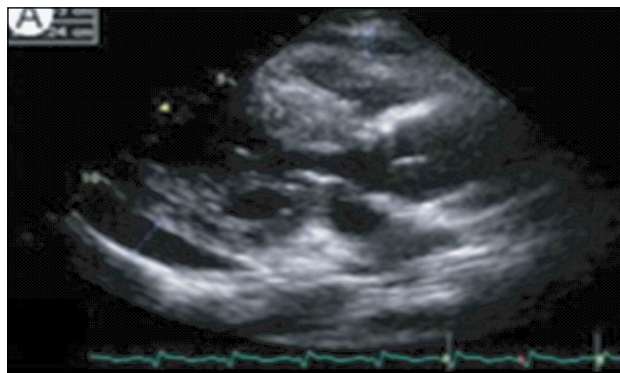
Echocardiography showed global wall motion abnormalities with a moderate amount of pericardial effusion.
